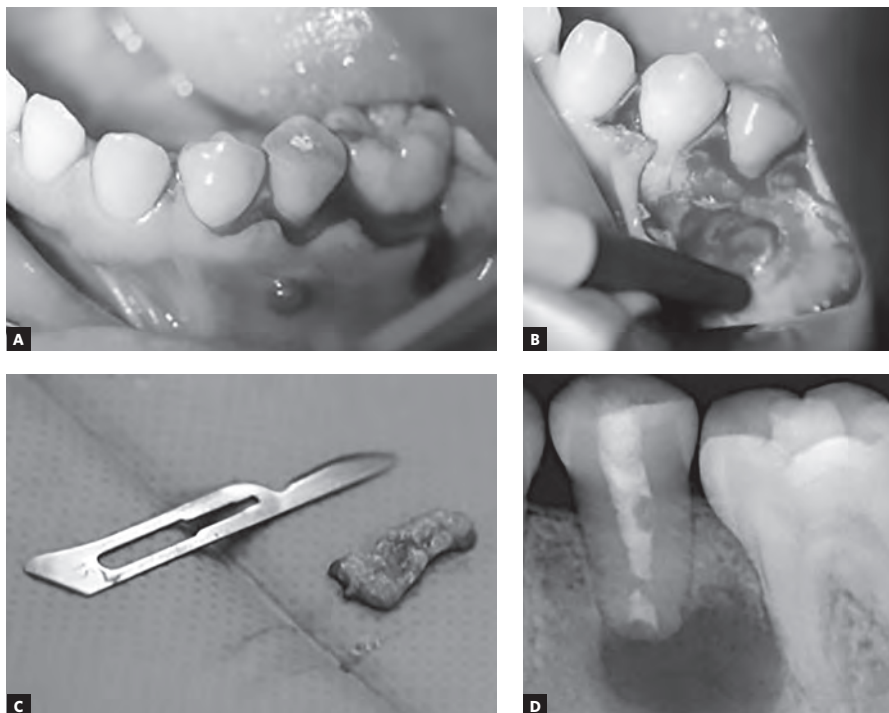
A) Intrasulcular incision was made from #3.3 to #3.6. It can be seen the temporary coronal filling and the fistula that had reappeared apical to #3.5. B) Visible loss of the external cortical bone located at #3.5. C) Image of the removed lesion before being sent for anatomopathological study. D) Periapical radiography of #3.5 just after the surgery.
